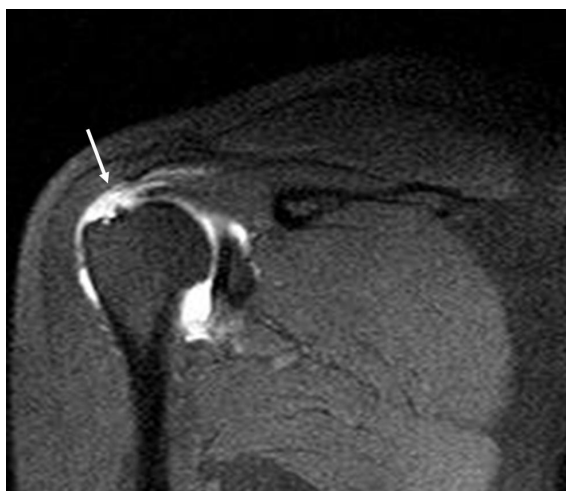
MR arthrographic image of 29-year-old man with partial thickness tear of supraspinatus tendon. Oblique coronal fat-saturated T1-weighted image shows abnormal contrast filling (short arrow) at the articular aspect of the supraspinatus tendon with SLAP lesion type 2 (long arrow). But there is no evidence of contrast leakage to the subacromial-subdeltoid bursa.
